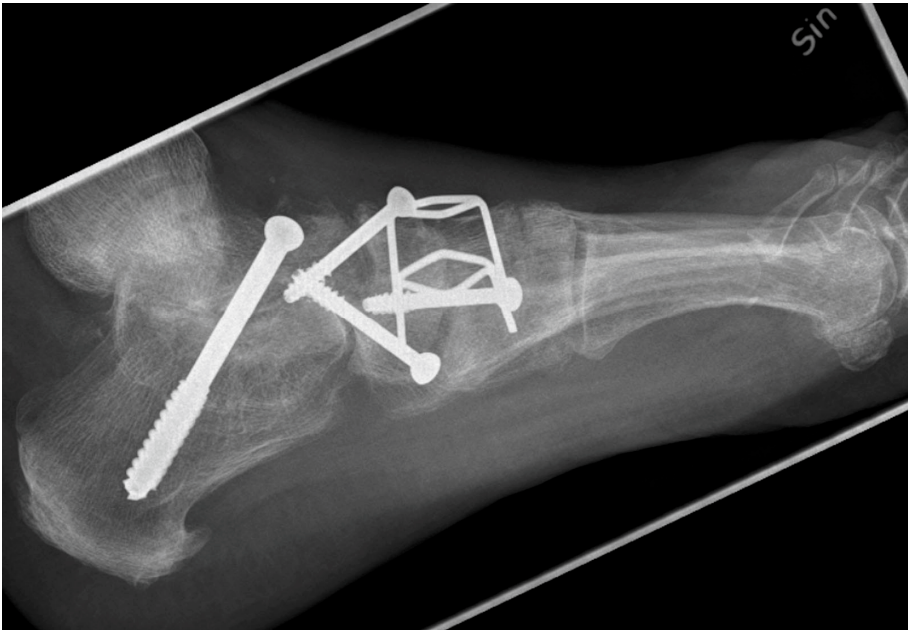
Radiograph demonstrating arthrodesis of multiple hindfoot joints
